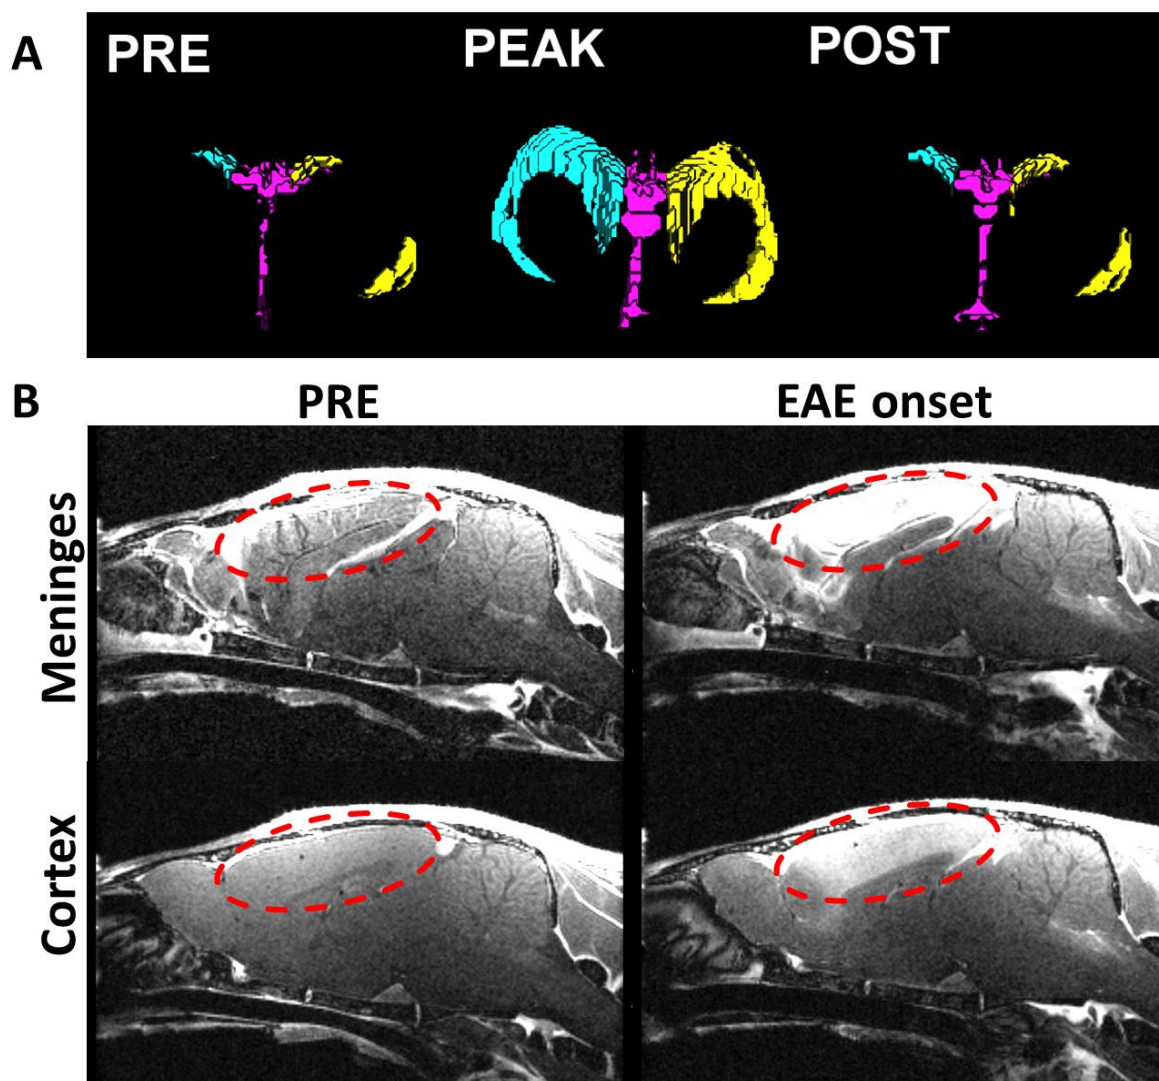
MRI analysis of ventricular enlargement and gadolinium enhancement.
